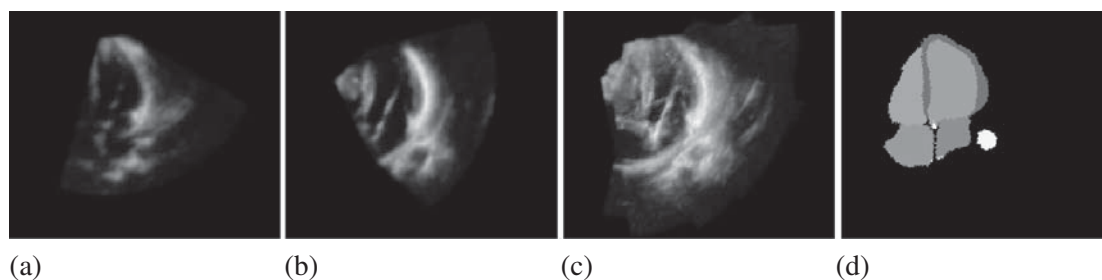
Example images and outputs from algorithms used during segmentation process, (a) view from apical scan; (b) view from parasternal view; (c) compounded image from 12 scans; (d) corresponding segmentation labels of (c).
